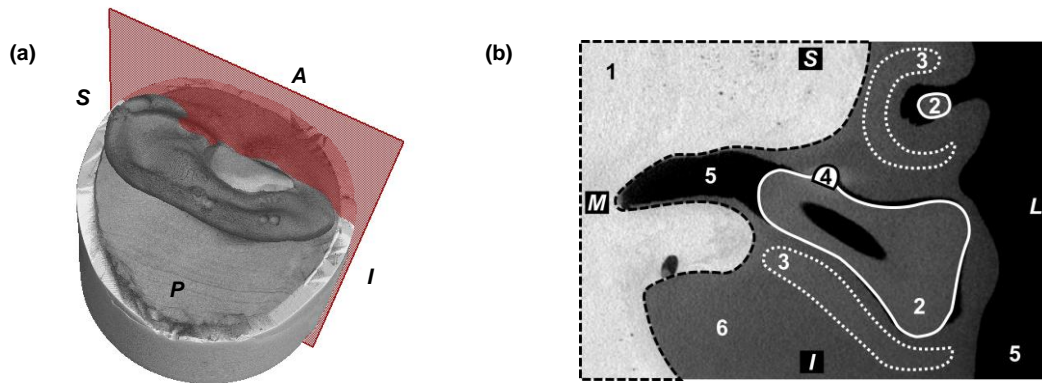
(a) 3D reconstruction of the occluded artificial ear from CT-scans measurements. The red plan indicates the cross section of the 2D view. (b) Coronal slice of the 3D reconstruction of the artificial ear. The regions delimited by the dashed black, solid white, dotted white and solid black lines are the bony part (1), the earplug (2), the cartilage (3) and the bead (4) respectively. The black part is the air (5) and the remaining dark gray part is the silicone mimicking the soft tissues (6).
